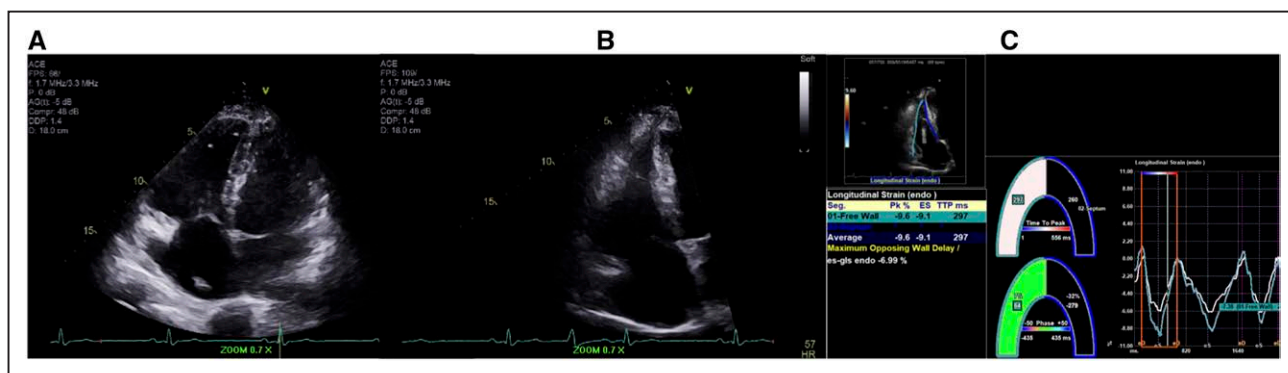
Echocardiography and right ventricle (RV) strain in arrhythmogenic right ventricular cardiomyopathy (ARVC).
